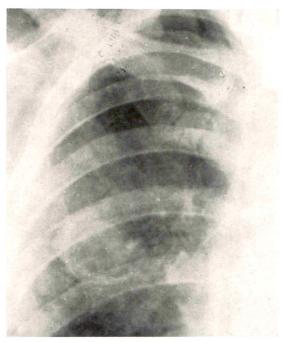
Case III. Follow-up chest roentgenogram made 4 days later shows clearing of the patchy densities. A lobulated, more defined density in the right upper lobe suggests formation of a traumatic cavity.
